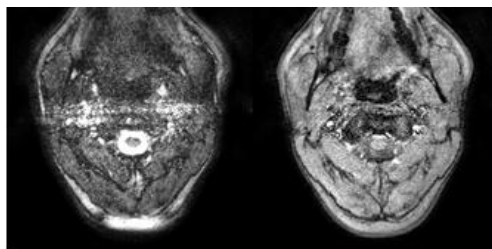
Magnitude images in the axial plane from the temporal center of the cardiac cycle at the level of C2 for PC-SSFP (left) and PC-MRI (right).
